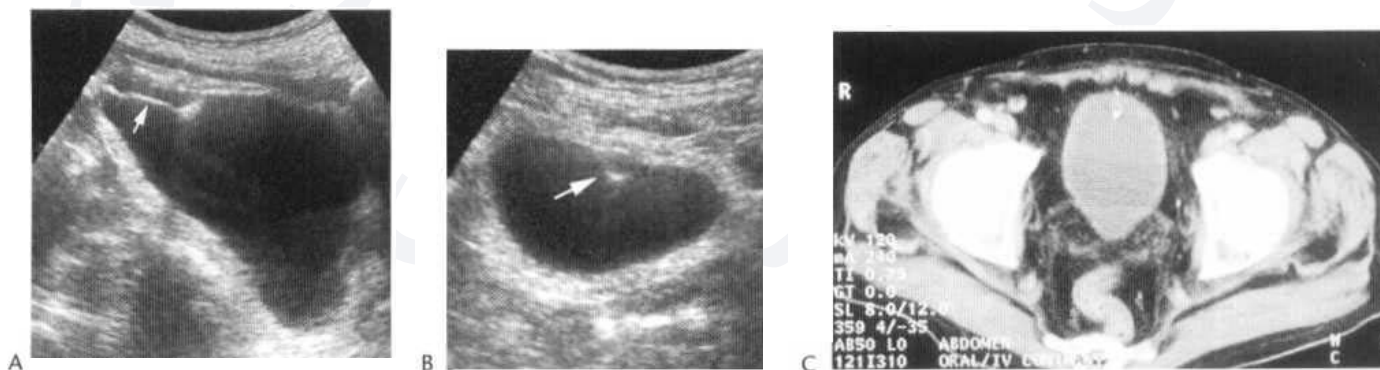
Longitudinal (A) and transverse (B) ultrasound showing a urachal cyst as a thin-walled cylindrical echo-free area (arrow). The CT (C) demonstrates analogous features with a small area of calcification.
